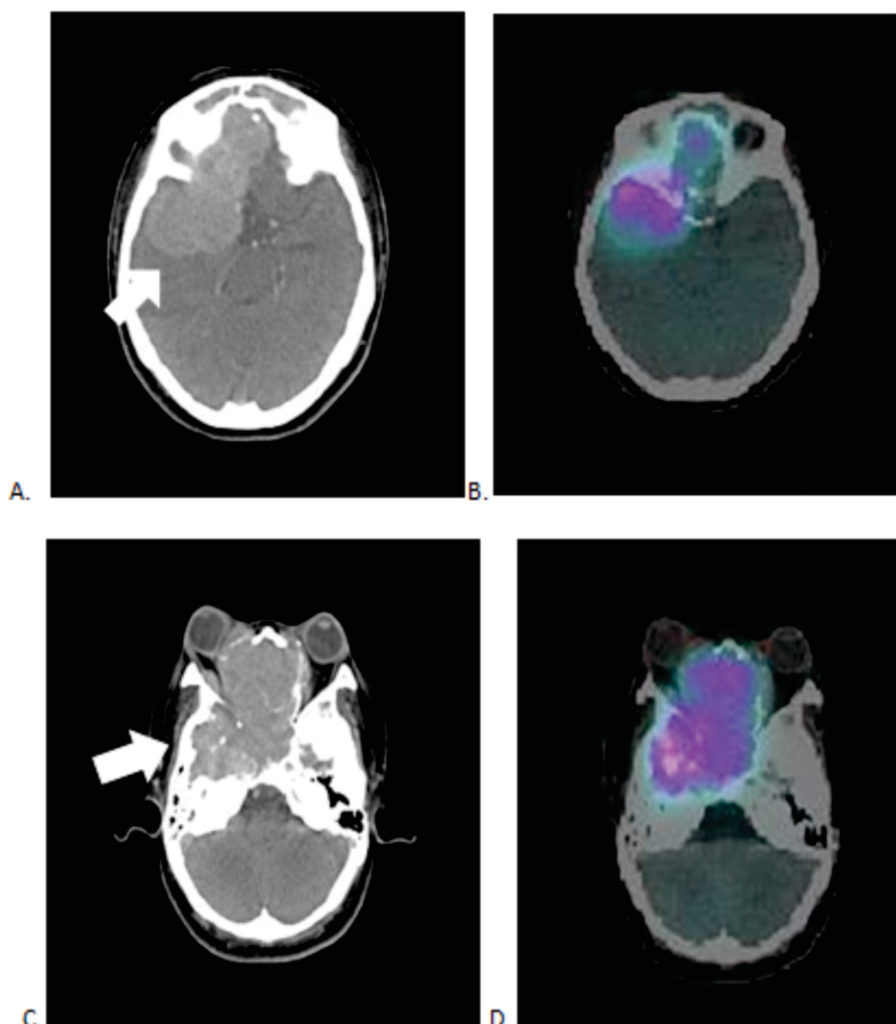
Initial positron emission tomography-computed tomography (PET-CT) scan of the patient. A. Enhancing mass at the nasal cavity with intracranial extensions (arrow) to the right frontal and temporal lobes of the brain with extensive vasogenic edema in the right frontal and temporal lobes with leftward midline shift. C. Increased lateral infiltration is noted with destruction of the lamina papyracea and the left extraconal orbital component of the mass abuts and displaces the left medial rectus muscle laterally. B. and D. High metabolic activity of the mass in the nasal cavity involving the paranasal sinuses, orbital structures, nasopharynx, and facial bones with intracranial extension.
